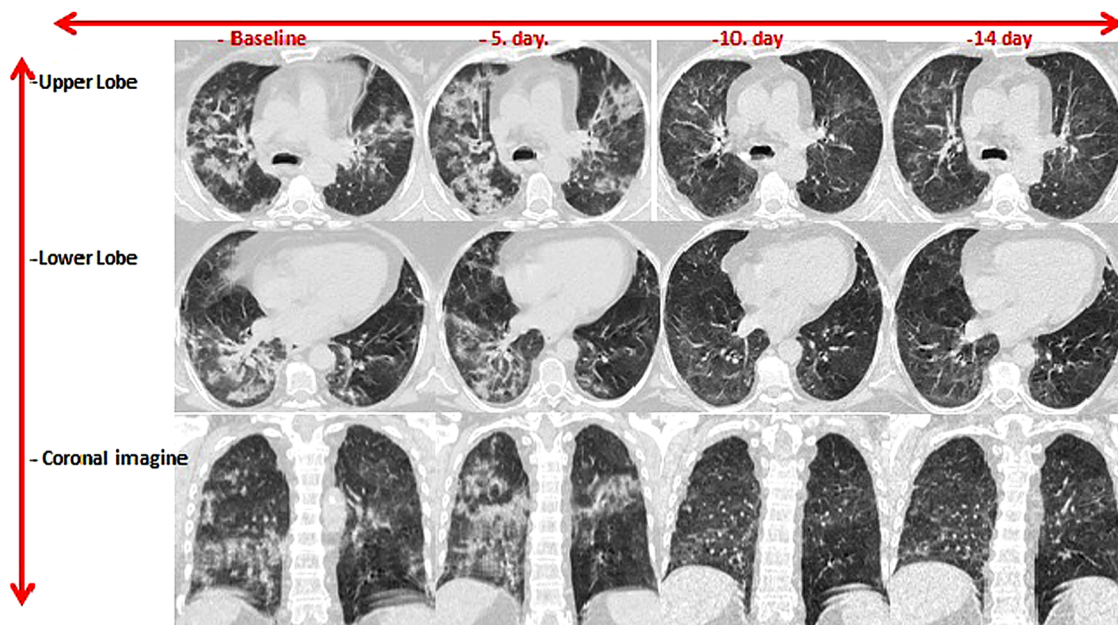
Thorax CT During The Follow-up of The Case
